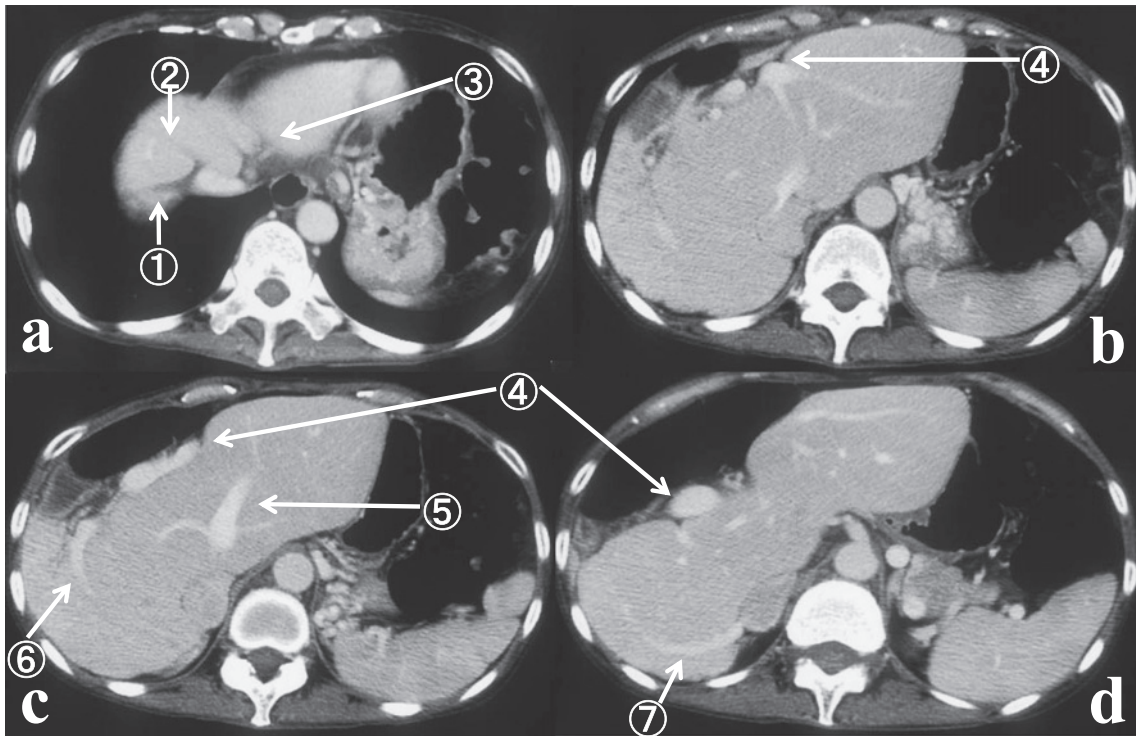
Abdominal computed tomography revealed obstructions and scars of the right ①, middle ②, and left ③ hepatic veins a). The caudate lobe was enlarged, and the portal vein ④ was displaced ventrally, without thrombus b). The drainage vein of the caudate lobe, the short hepatic vein ⑤ on the left side of the IVC, was dilated. The portal vein ⑥ and drainage vein ⑦ of segment 6 were visualized, with no signs of atrophy c) d).
